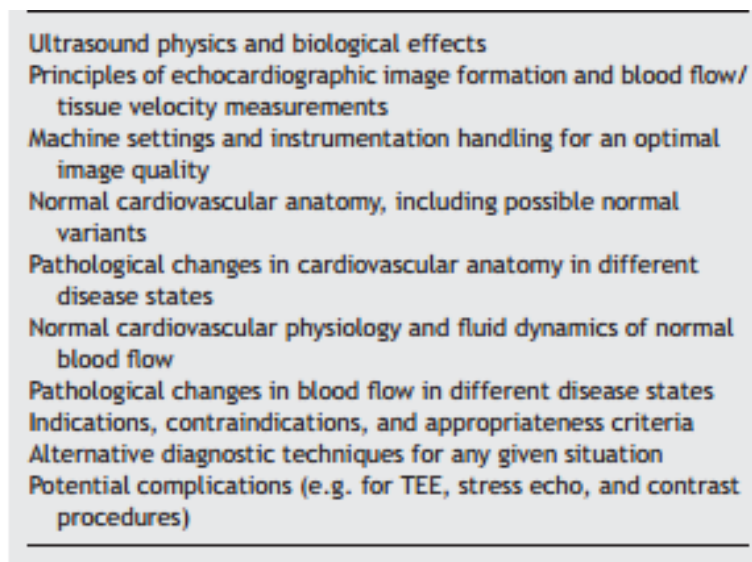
A summary of the training requirements for performance and interpretation of adult transthoracic echocardiography
